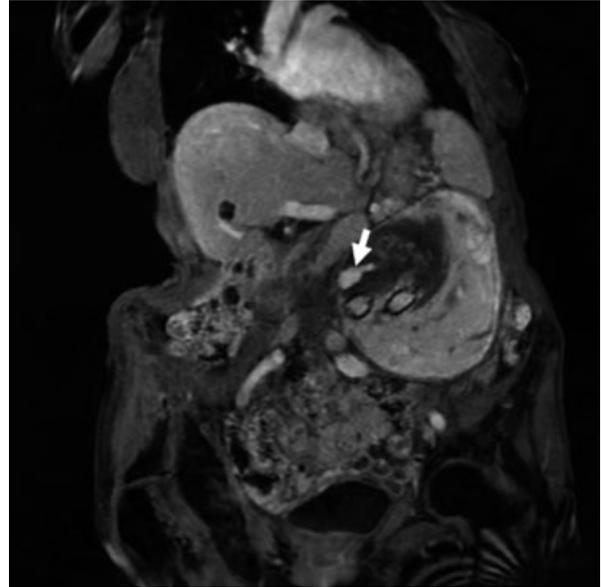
The T1-weighted CE-MRA sequence visualized contrast leakage into the aneurysm sac, proving the presence of the residual endoleak (corresponds to fresh blood inflow area visible on NCE-MRA; see Fig. 4 A, B)
